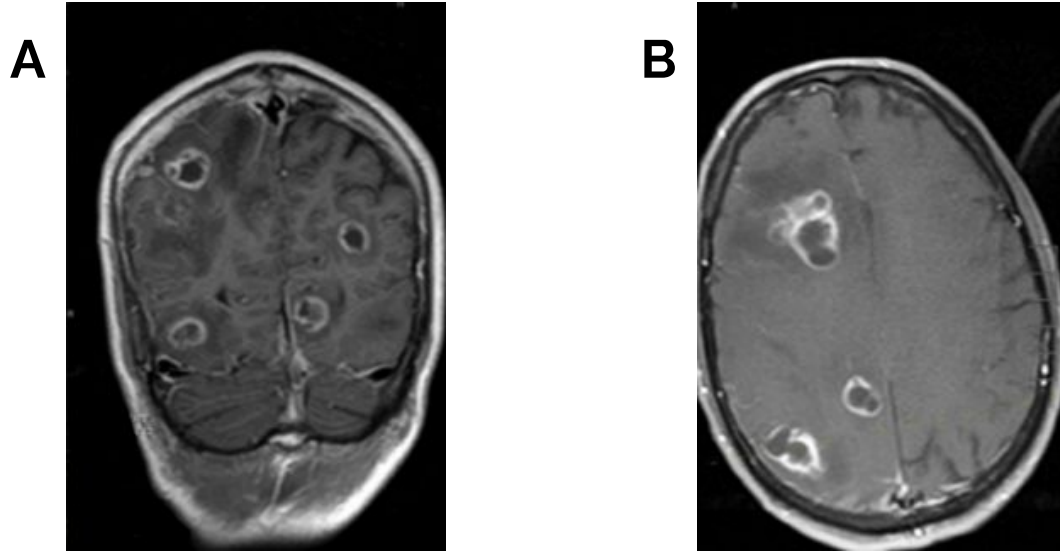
(A) Axial T1 post-contrast MRI showing multiple rim-enhancing cystic lesions involving the right frontal and parietal lobes. (B) Coronal T1 post-contrast MRI demonstrating multifocal abscesses with surrounding vasogenic edema and mass effect.
